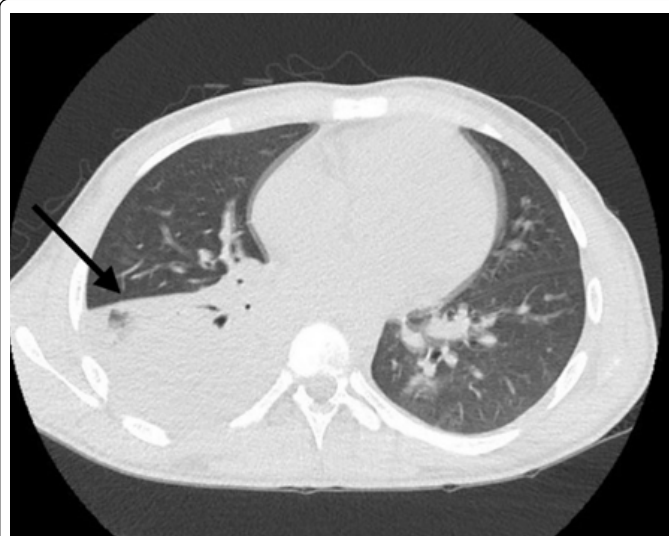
CT scan on day 4 of hospitalization: Small right pleural effusion. Extensive consolidation with air bronchograms in the right lower lobe.
